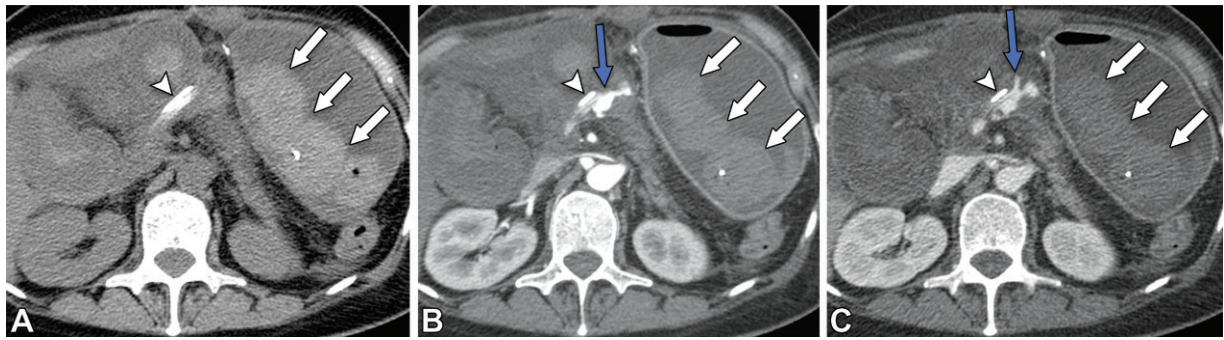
Sentinel clot related to active bleeding at the pancreaticojejunostomy anastomosis in a 65-year-old woman who presented with hematemesis and jaundice 12 days after she underwent the Whipple procedure for pancreatic adenocarcinoma. Axial noncontrast (A), arterial phase (B), and portal venous phase (C) CTA images show a sentinel clot in the stomach (white arrows) and contrast extravasation at the pancreaticojejunostomy site, which appears during the arterial phase (blue arrow in B) and changes in size, attenuation, and shape in the portal venous phase (blue arrow in C). There is a nasoenteric tube in place (arrowhead in all images).
